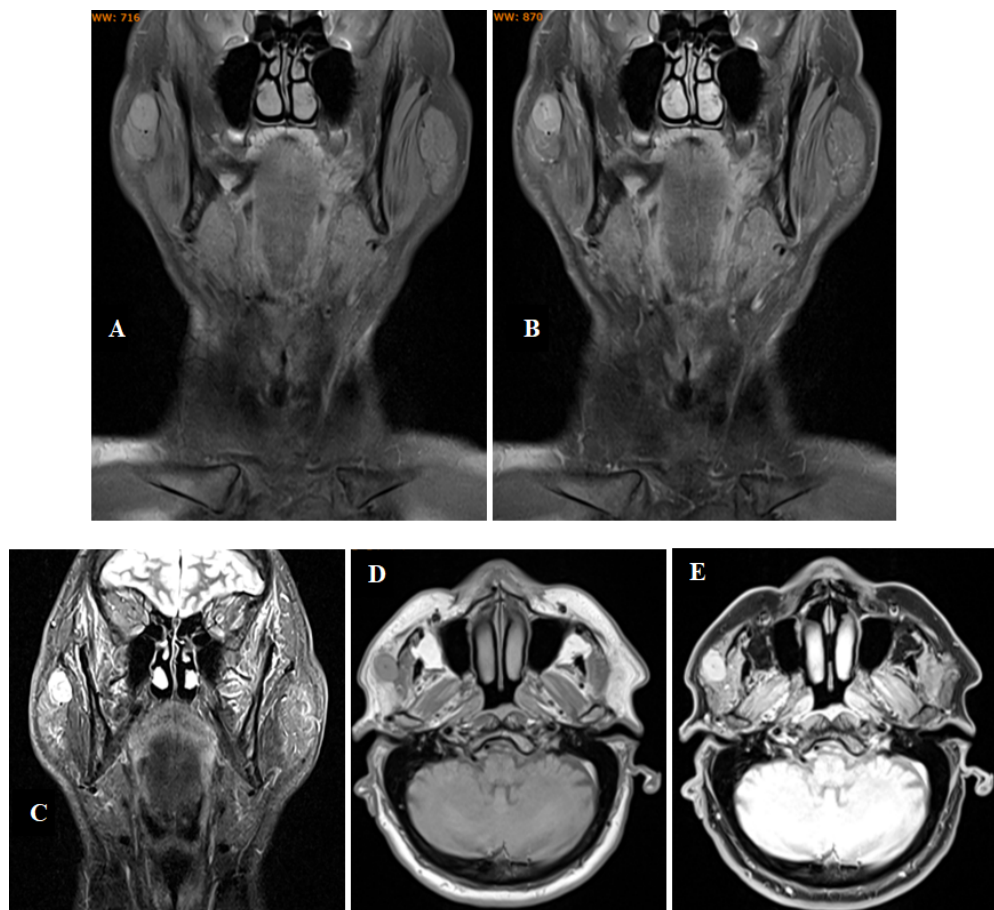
MRI of a 57-year-old male with a heterogeneous, irregular mass in the right parotid gland, characterized by undulating margins and 2–3 small cystic microlesions in the superior portion. The inferior component is solid, isointense on T1, and hyperintense on T2. Post-contrast images show peripheral enhancement of the solid portion, indicating moderate internal vascularization. Imaging features are consistent with a benign hypovascular lesion of mixed composition, suggestive of a pleomorphic adenoma. (A) T1-weighted turbo spin-echo with fat saturation (pre-contrast). (B) T1-weighted turbo spin-echo with fat saturation (post-contrast). (C) T2-weighted turbo inversion recovery magnitude (T2 TIRM). (D) T1-weighted turbo spin-echo with fast Dixon (pre-contrast). (E) T1-weighted turbo spin-echo with fast Dixon (post-contrast).
